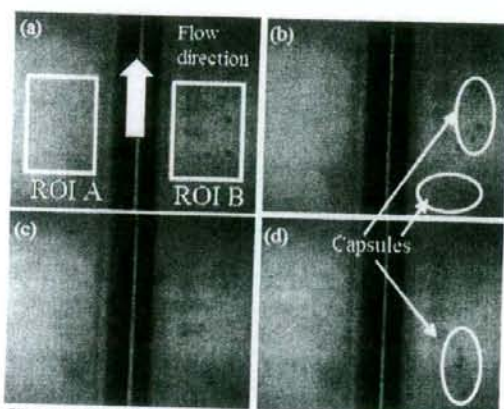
Time series images of the observed area by 500 [fps] after injection of capsules suspension with ultrasound emission.
